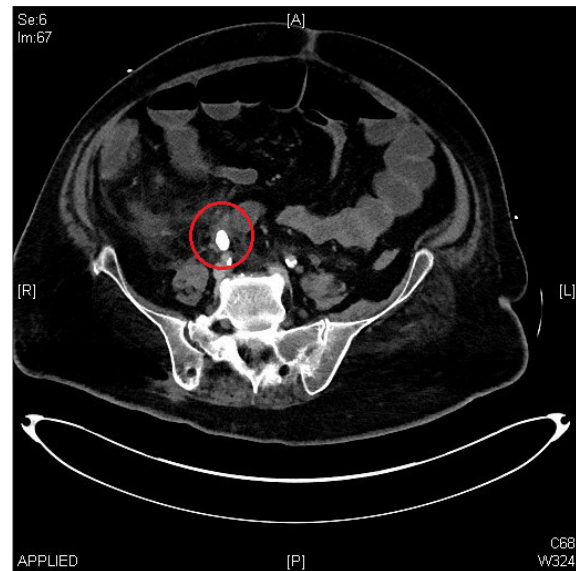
CT of the abdomen and pelvis showing signs of right sided obstructive uropathy and pyonephrosis:
